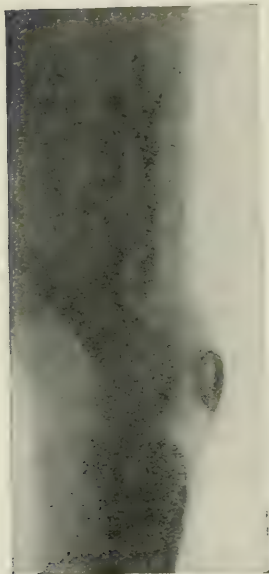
X-RAY SHOWING FRACTURE OF FEMUR WITH BACKWARD DISPLACEMENT OF THE LOWER END, CAUSING EXTERNAL POPLITEAL PALSY.
